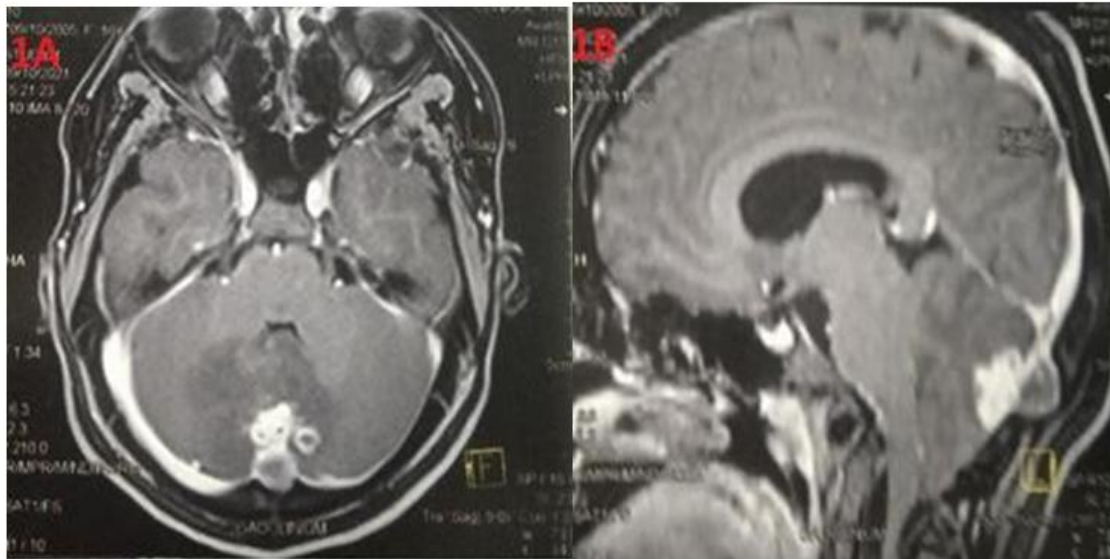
T1-weighted axial MR images ,*Figure 1B* : T1-weighted sagittal MR image showing an intra axial expansive process of the inferior vermis, arnold chiari malformation type 1 , medial cerebrospinal dermoid cyst and median occipital bone opening without fluid sac or nerve herniation.
